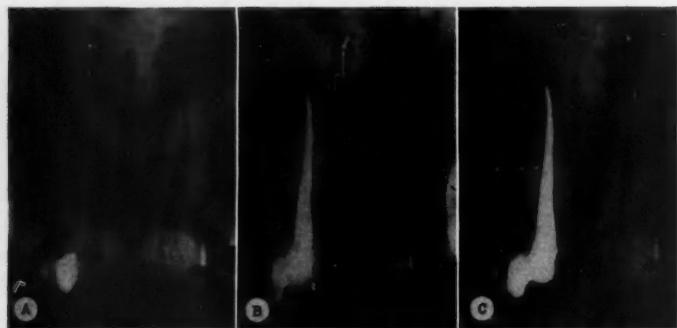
Series of roentgenograms of a maxillary right central incisor that was obturated using the primary and secondary silver point technique. A, At initiation of therapy. B, At completion of obturation. C, One year after completion of therapy, demonstrating complete resolution of apical pathosis.
